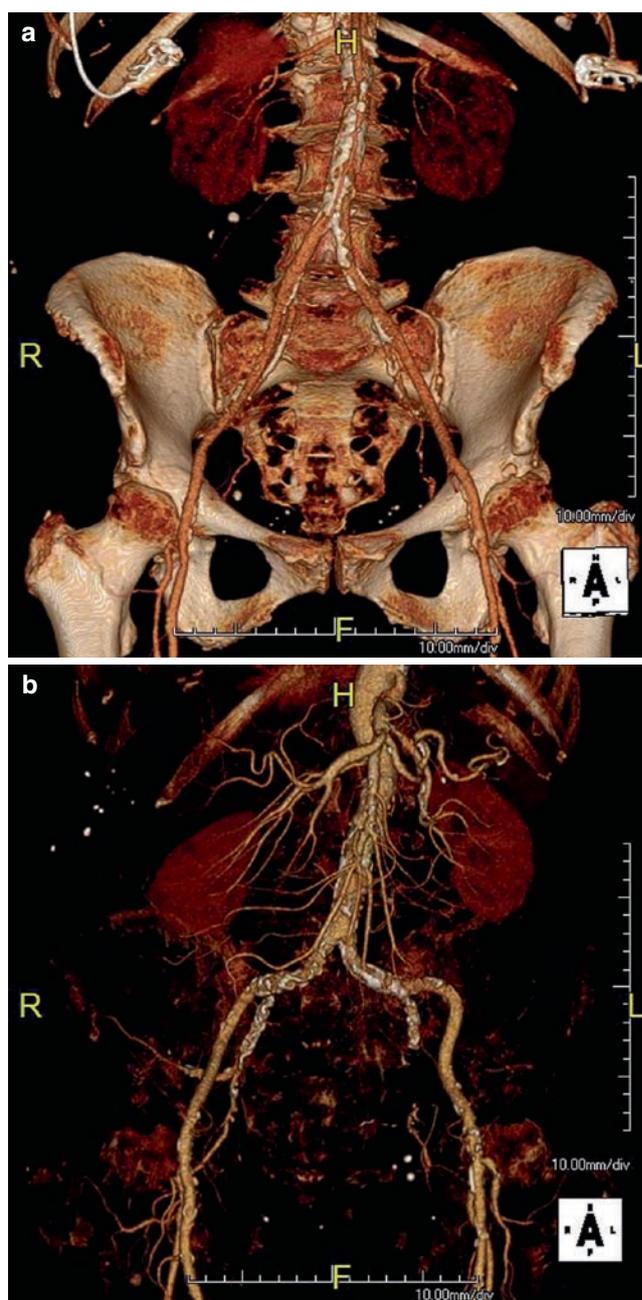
Evaluation of femoral access prior to transfemoral aortic valve implantation using 3D reconstruction of CT-angiography. (a) Patient with no tortuosity and little calcification of iliac arteries (particularly on the right side). (b) Patient with significant tortuosity and marked calcification of iliac arteries
